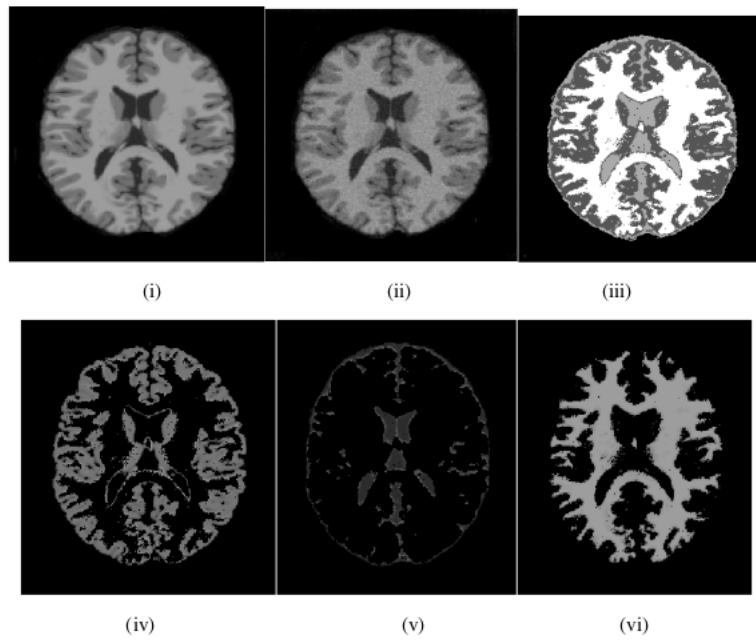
(i) MRI T1-88, (ii) MRI with 3% noise, (iii) MRI segmented using ACO-FCM, (iv) MRI with Gray, (v) CSF, (vi) MRI with White
